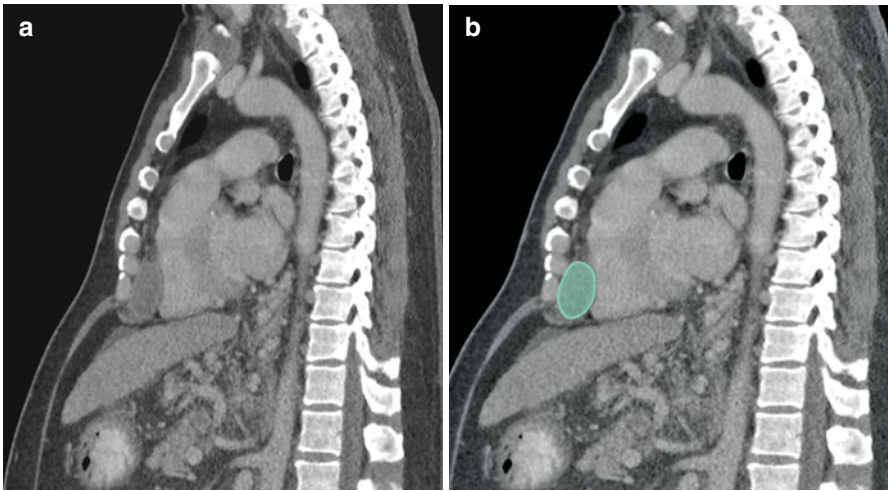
(a, b) Sagittal reformatted CT scan of the thorax and upper abdomen shows enlarged pericardial lymph node in a case of hepatocellular carcinoma (*green*)
